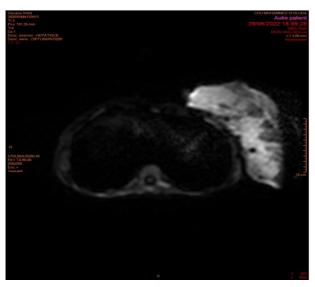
MRI diffusion sequence
